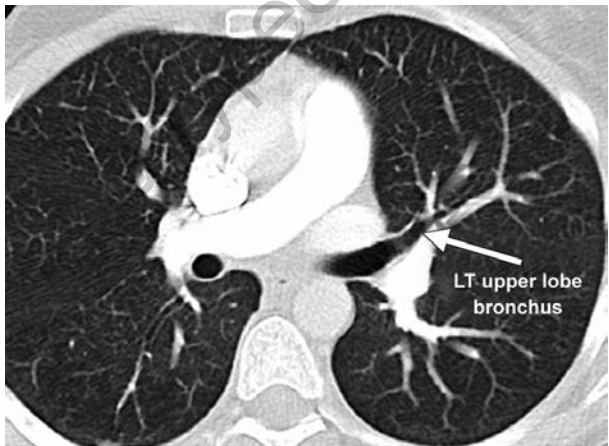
CT chest at the level of the left main stem bronchus showing the left upper lobe and bronchus
